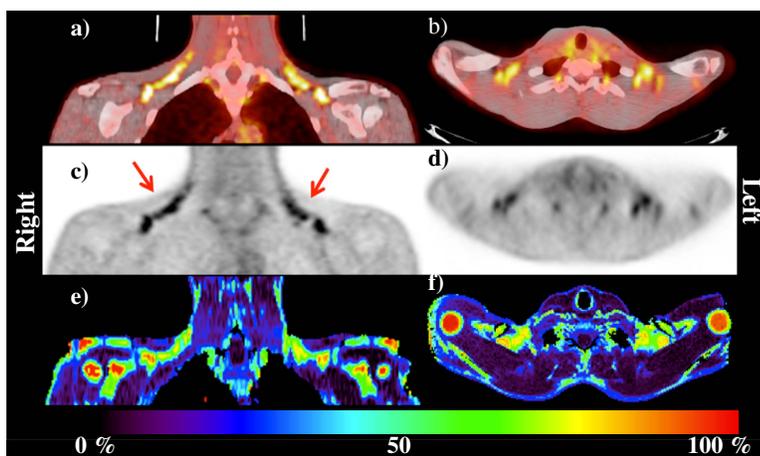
Fused PET-CT (a,b), PET only (c,d), and FWMRI-derived Fat Fraction map (with colorbar) (e,f) of coronal and axial slices through the shoulder region. Red arrows in (c) point to ¹⁸F-FDG uptake into the BAT during the cold PET scan. This region corresponds with the regions of lower fat-fraction in (e) and (f).
